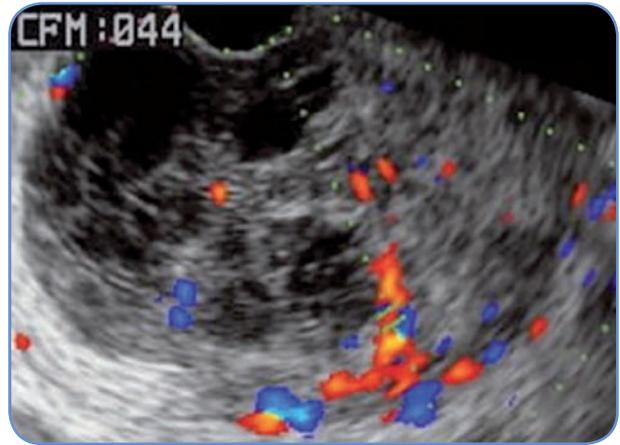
Increased Doppler flow in a malignant ovarian tumour
